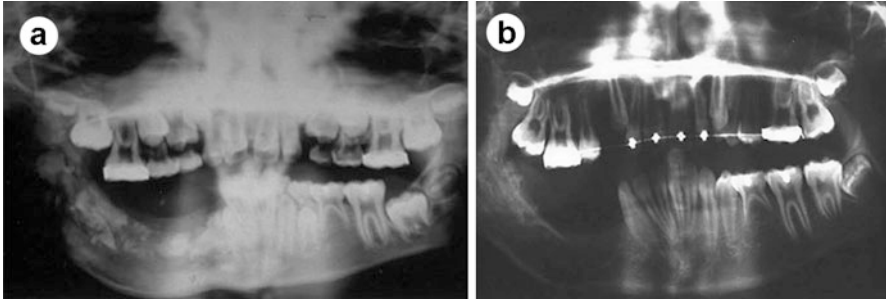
(a) Six-month postoperative panoramic radiograph showing gradual replacement of the graft by bone. (b) Three-year postoperative panoramic radiograph showing complete replacement of the graft material by bone, good bone height, and contour with no recurrence of odontogenic keratocyst. (D.C. Stanton et al. 2004, reprinted with permission)
